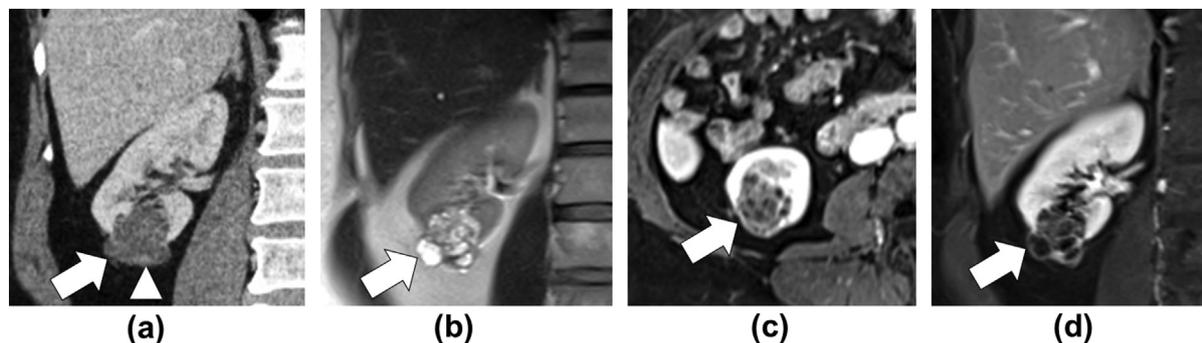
A 54-year-old woman with right lower pole cystic mass detected incidentally on CT. (a) Coronal enhanced CT image shows irregular cystic lesion in the lower pole of the right kidney (arrow) with a single, thin enhancing septa (arrowhead). The lesion was characterised as a Bosniak 2F cyst on CT. MRI was performed during next follow-up. (b) Coronal T2-weighted ssFSE, (c) axial, and (d) coronal T1-weighted post-gadolinium-enhanced images reveal substantially more numerous and thicker septa, some with measurable and nodular enhancement (arrows). In this instance, MRI upgrades the Bosniak category from Bosniak 2F to Bosniak 3.
